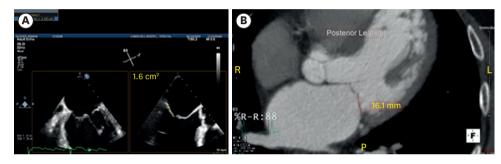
(A) shows an xplane of the A2/P2 segment of the mitral valve from the commissural view. The posterior leaflet measured on the long-axis view is around 1.6 cm² on 3-dimensional transesophageal echocardiography. (B) shows the posterior leaflet measurement on multi-detector computed tomographic angiography measured at 1.61 cm.
